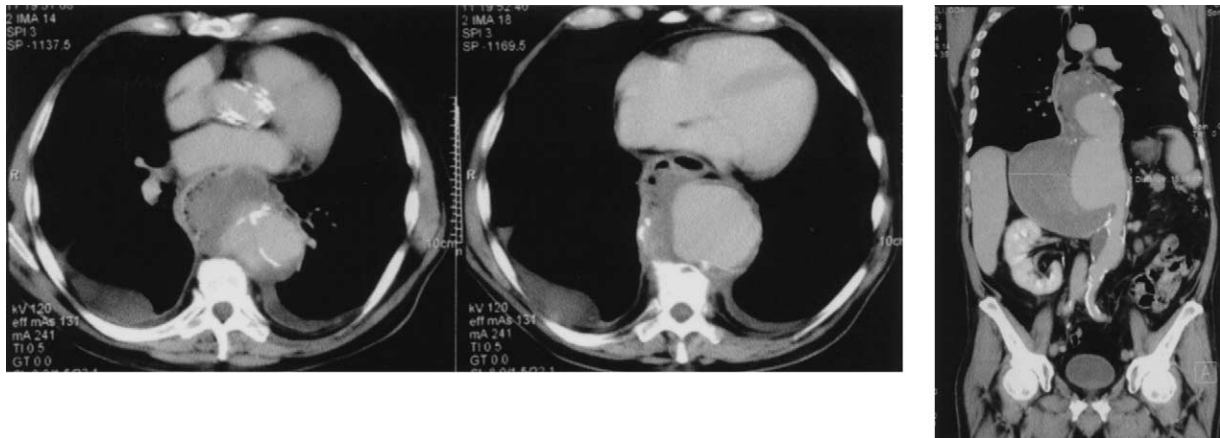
Computed tomography showing air bubbles within the mural thrombus of a thoracoabdominal aortic aneurysm ruptured into the esophagus.
